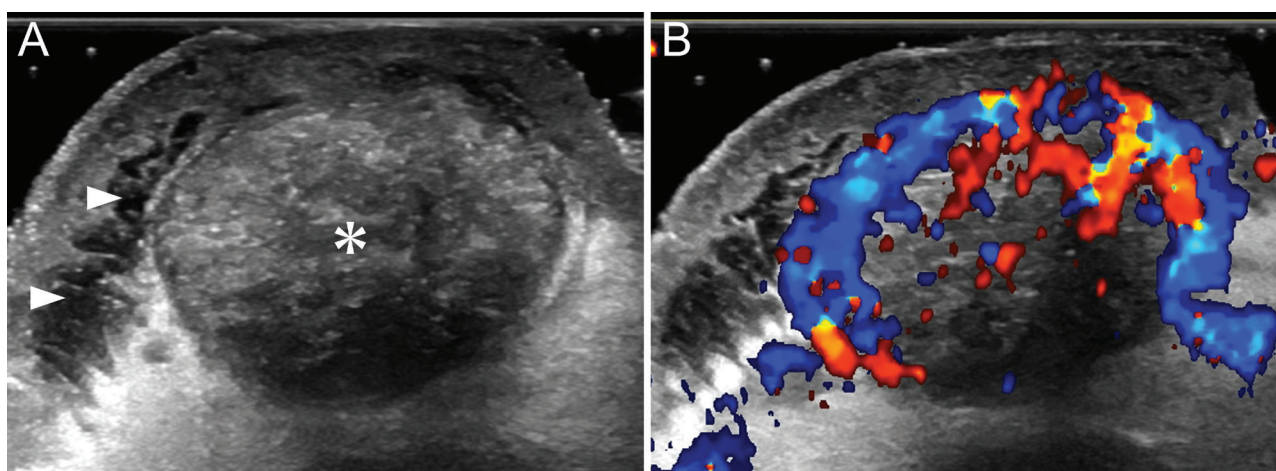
Greyscale and colour Doppler ultrasound images. (A) Greyscale ultrasound image showing an oval-shaped heterogeneous hyperechoic mass involving the dermis and subcutis (asterisk) with scattered hyperechoic punctate foci and posterior acoustic shadowing. The dermis contains anechoic areas (arrowheads). (B) Colour Doppler imaging showing intratumoral hypervascularity.
